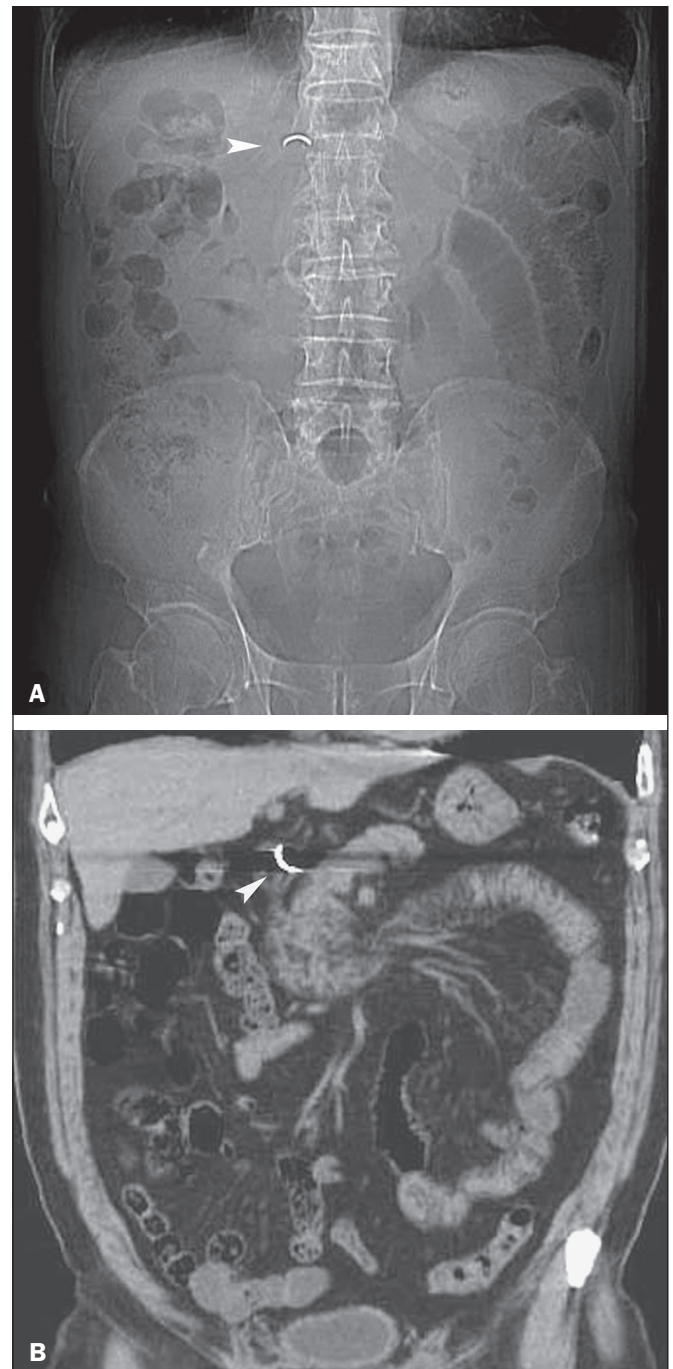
A 65-year-old woman who ingested a false tooth while eating peanuts. A: Anteroposterior radiograph of the abdomen showing a metal foreign object (arrowhead) most probably situated in the superior part of the duodenum. B: Coronal multiplanar reformatted CT image, obtained a few hours later, showing that the false tooth fragment (arrowhead) lodged near the superior duodenal flexure and having changed its orientation.
